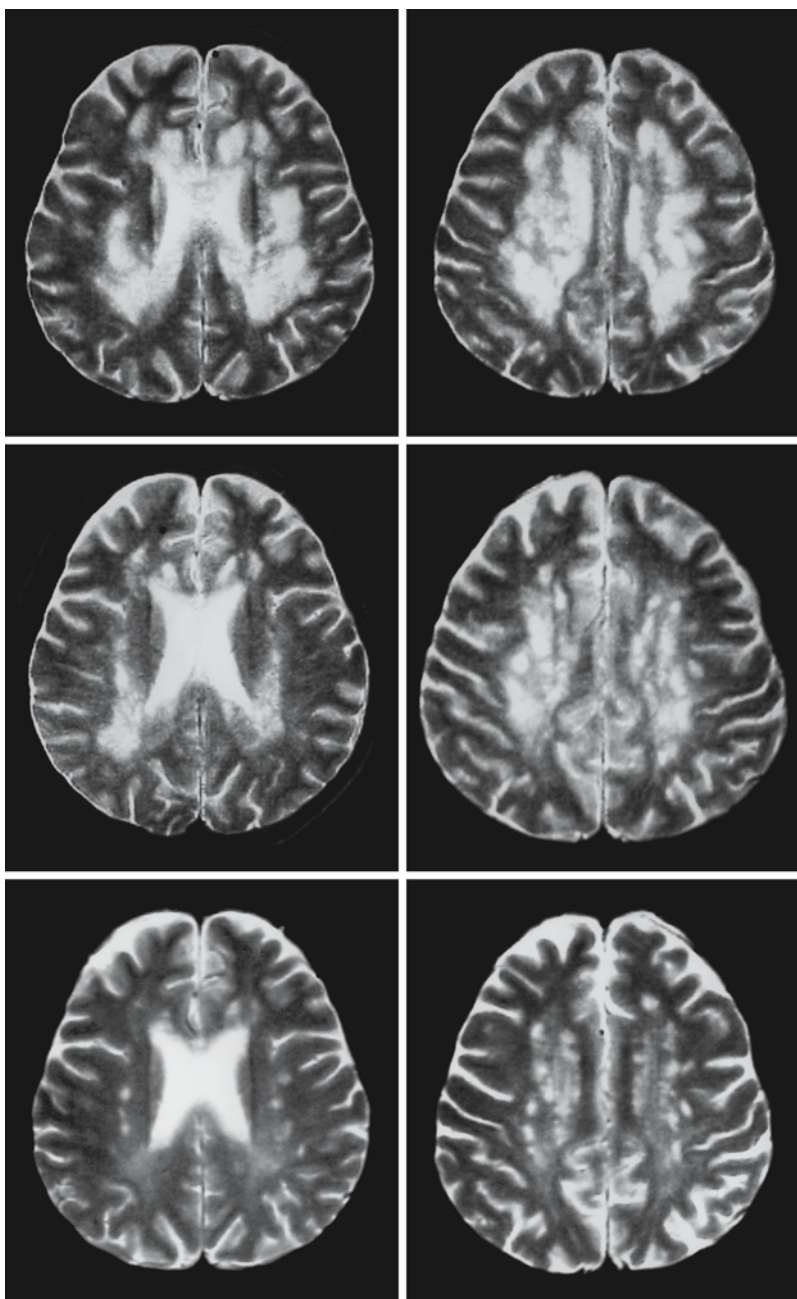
A 51-year-old female patient with cobalamin deficiency. The first MRI (*first row*) was obtained before treatment and shows extensive, patchy cerebral white matter abnormalities with sparing of the U fibers. Follow-up MR images 2 months after installment of cobalamin supplementation (*second row*) and 44 months after initiation of treatment (*third row*) show a striking improvement, especially on the third MRI. From Stojavljević et al. (1997), with permission
